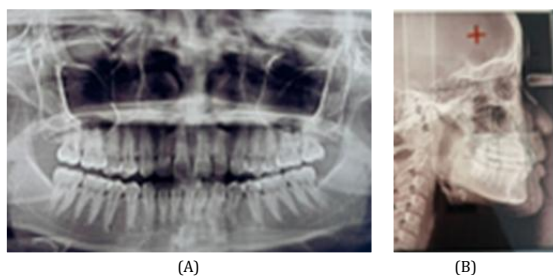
(A) Patient's panoramic radiograph, (B) Patient's cephalometric radiograph
